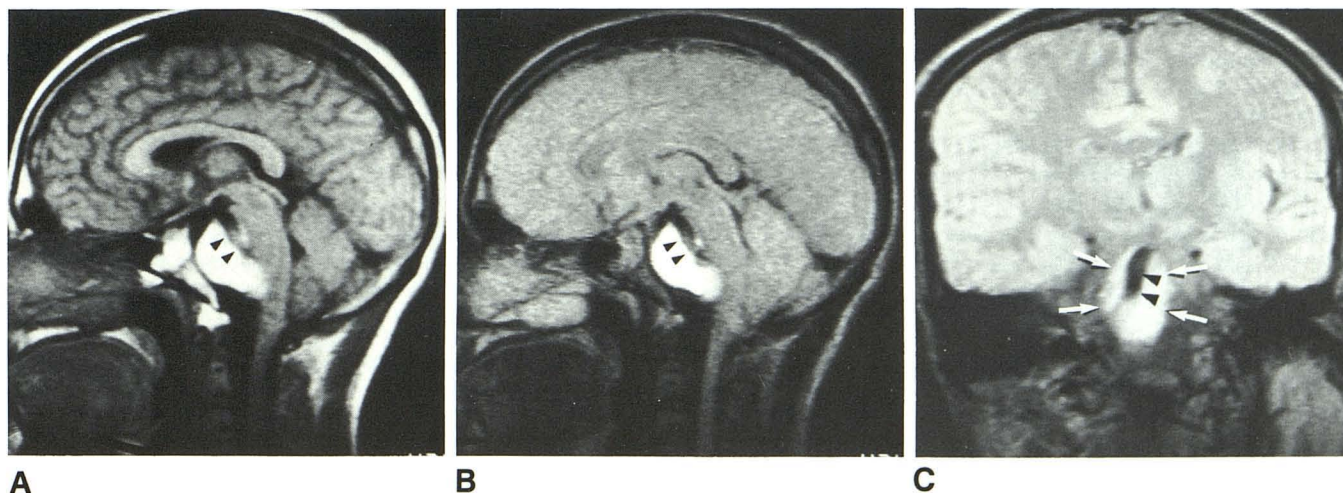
A, Spin-echo T1-weighted MR image (TR = 530, TE = 30). Note high signal from extraaxial mass within preponine cistern that displaces brainstem posteriorly. Note linear region of low signal posteriorly (arrowheads in A and B), indicating flowing blood within residual lumen of aneurysm. B, Spin-echo T2-weighted MR image (TR = 2060, TE = 90). Mass remains mostly higher signal, confirming the presence of blood clot. C, Spin-echo coronal MR image (TR = 2240, TE = 30). Note residual lumen of aneurysm (arrowheads) surrounded by clotted blood. True aneurysm wall is defined by margin of thrombus (arrows).
